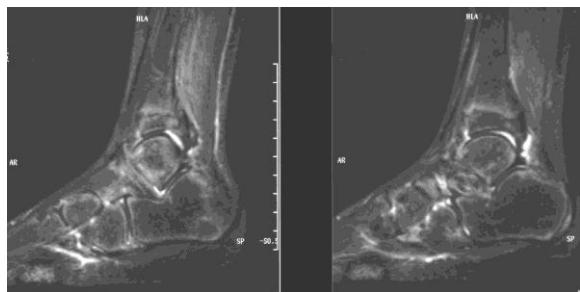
An 11-year-old boy sustained a sport injury of his right ankle while playing football. Due to the severity of the local symptoms and signs a MRI was performed 6 weeks post-injury. Short tau inversion recovery images showed bone bruising of the distal tibia and fibula, as well as of the talus, calcaneus and navicular. Fluid signal was also evident around the talus.
